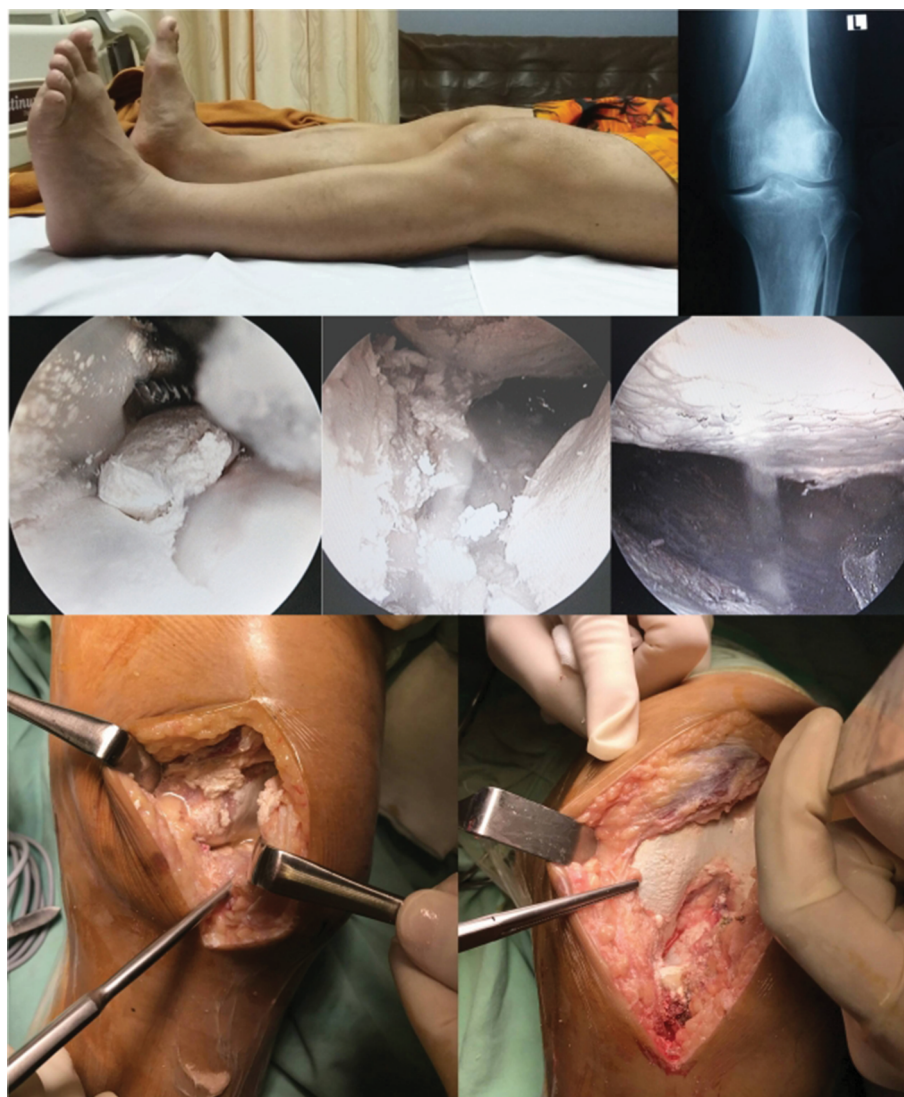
Clinical picture of knee in fixed 10 degree flexion and normal radiography.
